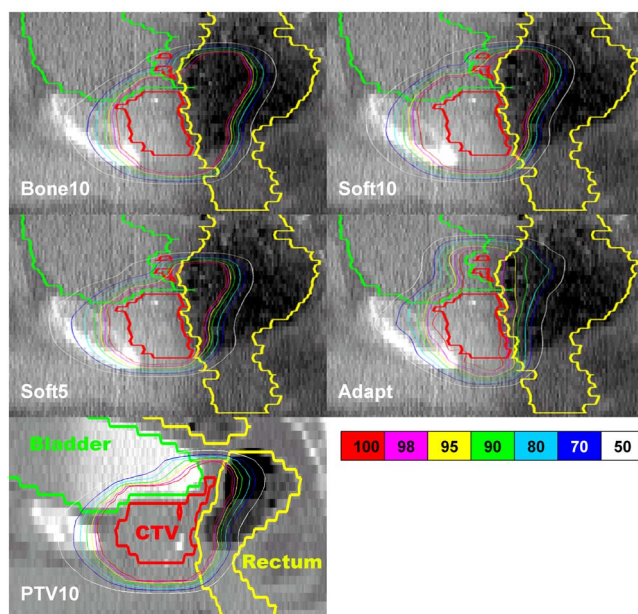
Dose distributions from one representative day with the four IGRT techniques: bone10, soft10, soft5, adapt, and the original plan, PTV10. The plans from bone10, soft10, soft5, and adapt techniques are overlaid on daily CBCT images while the original plan is overlaid on the planning CT images.
